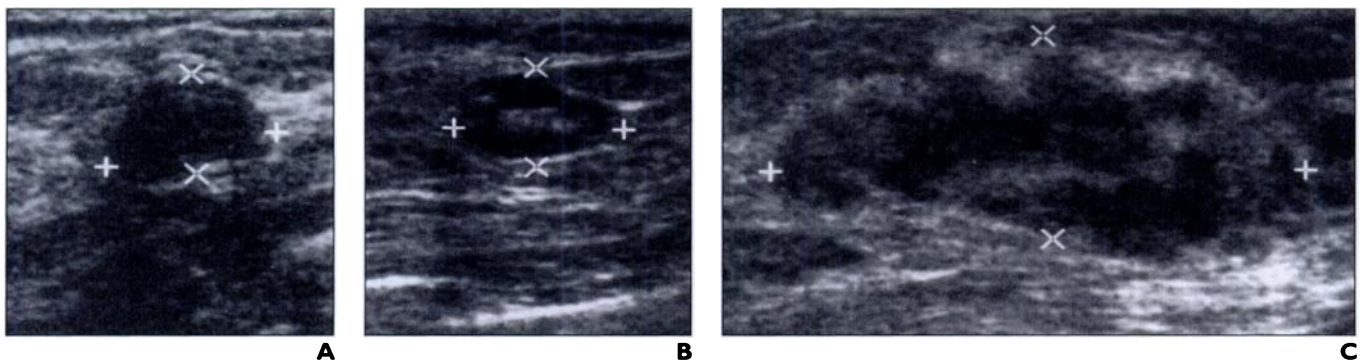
Breast sonography of 42-year-old woman.
